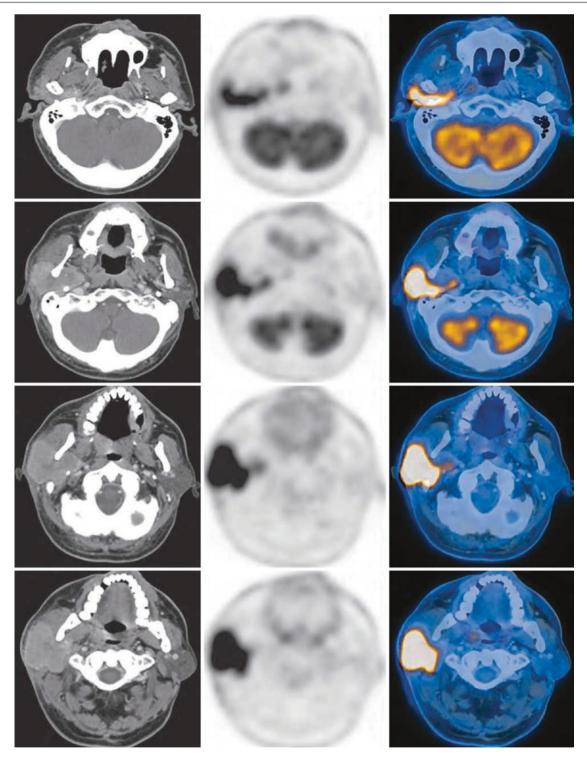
¹⁸F-FDG PET/CT image of right salivary duct carcinoma. The lobulated soft tissue density mass of the right parotid gland showed intense FDG uptake. The SUV was about 17.7, and the largest layer was about $4.6 \, \text{cm} \times 5.4 \, \text{cm}$. There were low-density necrosis areas and small punctate calcifications with sparse radioactive distribution, and the enhanced scan showed obvious inhomogeneous enhancement. The
